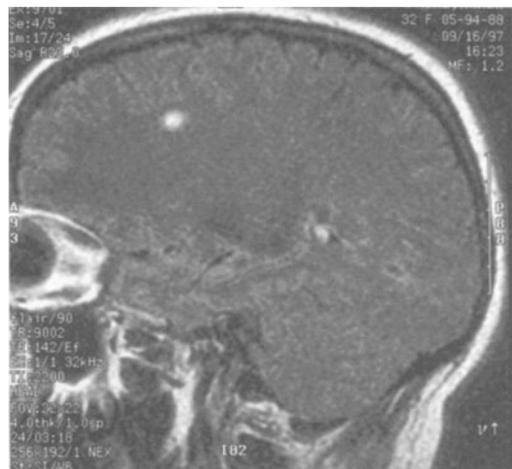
Multiple sclerosis involving brain. Case 9-12. MRI. See text.
